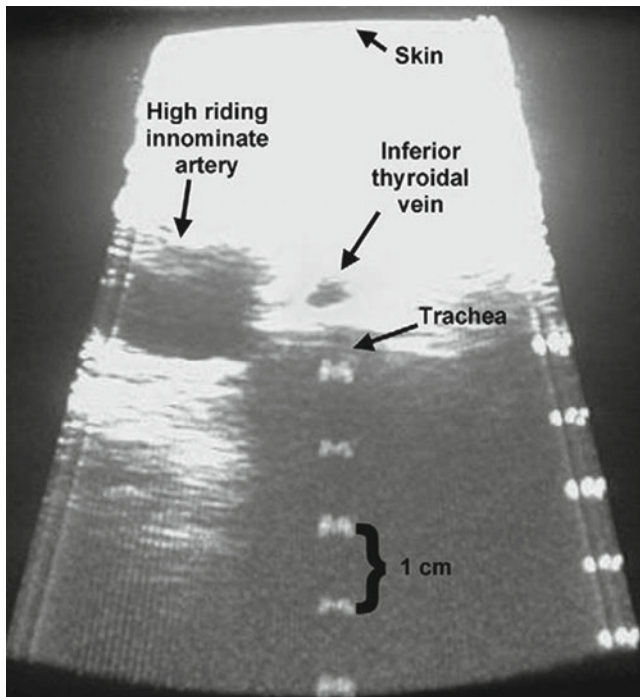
Ultrasound of the base of the neck just cephalad to the sternal notch in an obese patient revealing a nonpalpable high-riding innominate artery and a large inferior thyroidal vein (Reprinted from deBouisblanc BP. Percutaneous dilational tracheostomy techniques. *Clin Chest Med* 2003;24(3):399–407. With permission from Elsevier)
